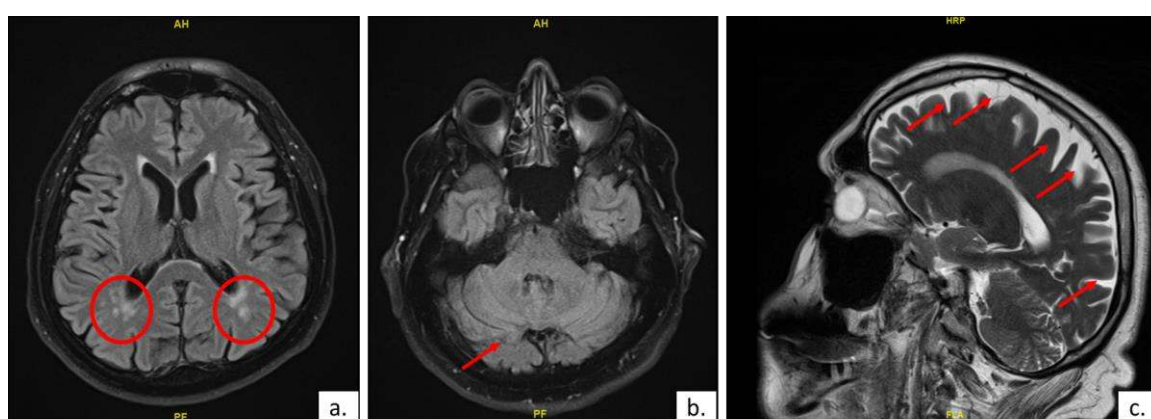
Cranial MRI sections showing ischemic gliotic focus in the periventricular white matter (a), cerebellar folios mildly prominent (b), and the depth and width of the sulci and fissures have increased (c) of the index case of Family 5 (M.S.)
